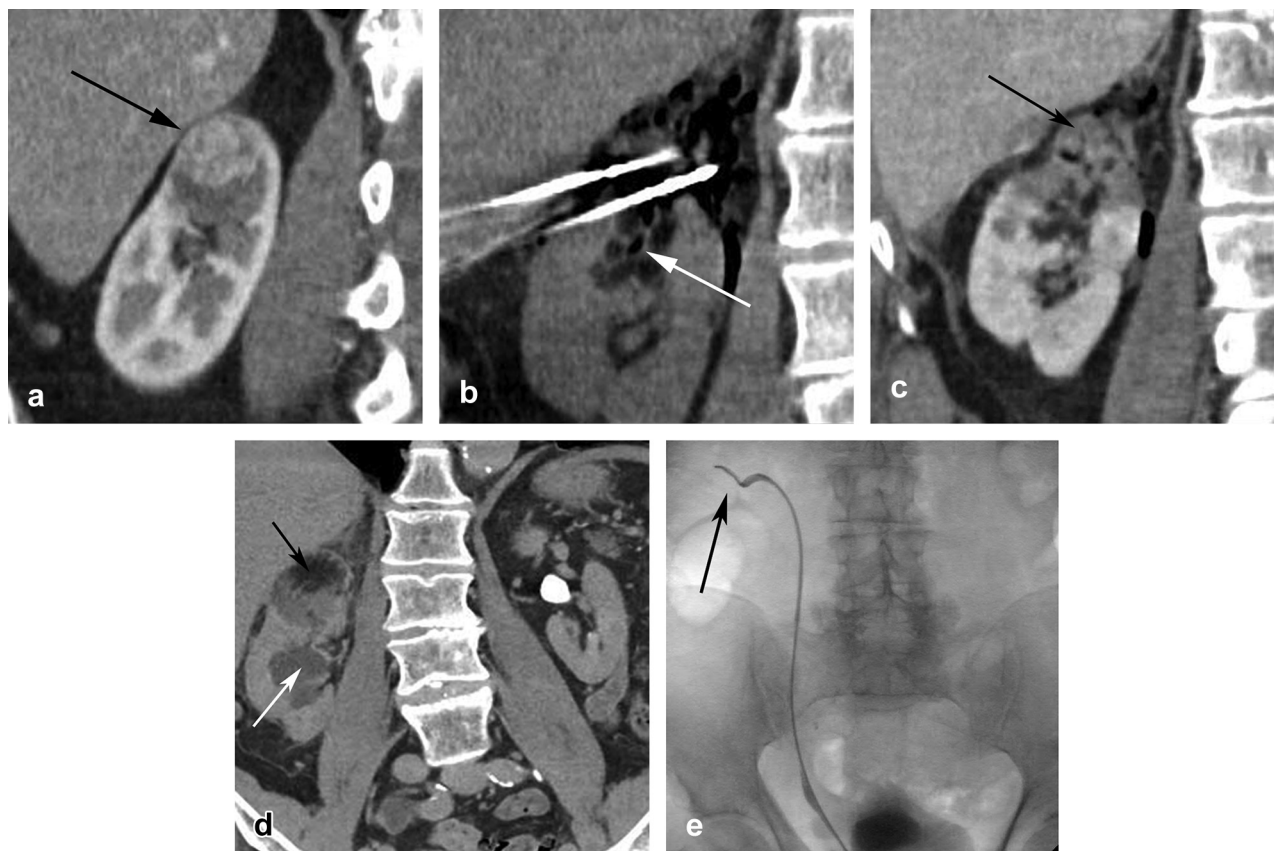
Patient 1 underwent ablation of a 2.5-cm mass in the upper right kidney. (a) Coronal reconstructed CT image with intravenous contrast enhancement shows the 2.5-cm mass in the upper right kidney (black arrow). (b) Coronal reconstructed CT image obtained during MW ablation shows the 3 antennas in the mass with adjacent soft tissue gas and gas within the collecting system (white arrow). (c) Coronal reconstructed CT image with intravenous contrast enhancement obtained immediately after ablation shows an ablation defect encompassing the index renal mass (black arrow) but not extending to the UPJ. (d) Delayed coronal reconstructed CT image with intravenous contrast enhancement obtained 3 months after ablation shows a large evolving ablation site (black arrow) with associated fat necrosis and new dilatation of the intrarenal collecting system (white arrow) and absence of contrast material excretion from the right kidney. (e) Fluoroscopic image obtained during retrograde pyelography with attempted ureteral stent placement. No contrast material could be refluxed into the right renal pelvis. A pinhole UPJ stricture was noted that a wire would not pass beyond (black arrow).
